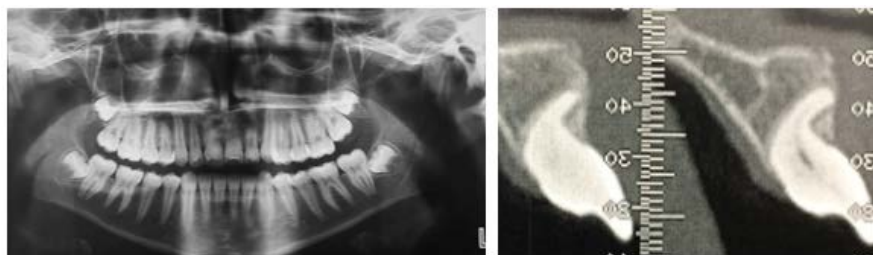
Panoramic and cone beam images after treatment.
